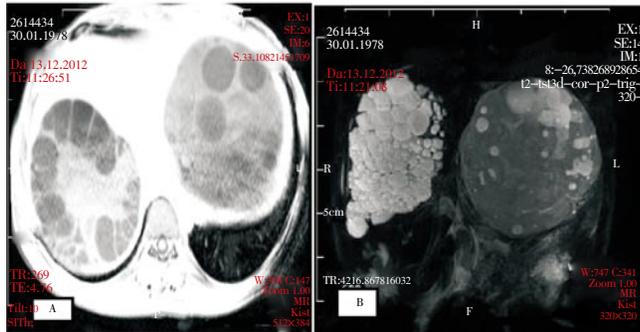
Abdomen MRI revealing two separate cystic liver lesion.
